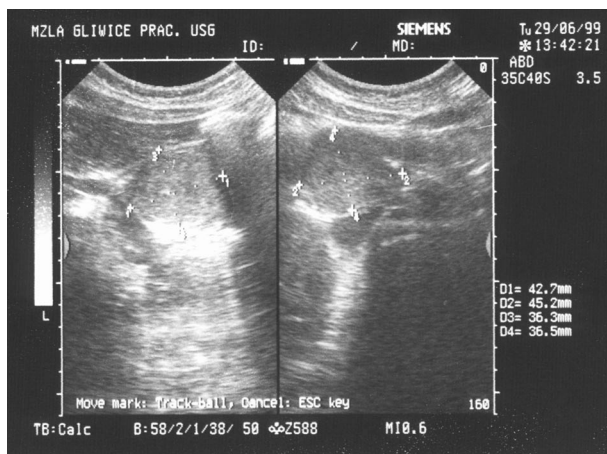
Preoperative ultrasound image
